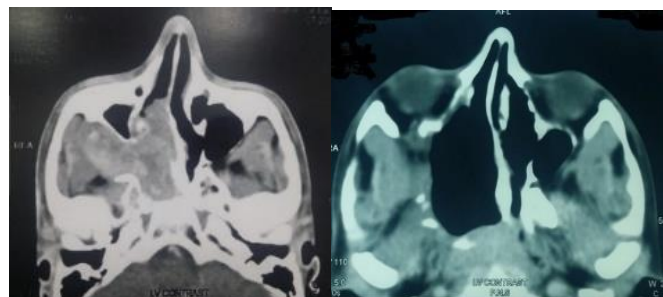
CT imaging of (a) a case with JNA of stage IIIa involving PPF, ITF, nasal cavity. (b) Post-operative imaging with no recurrence.
